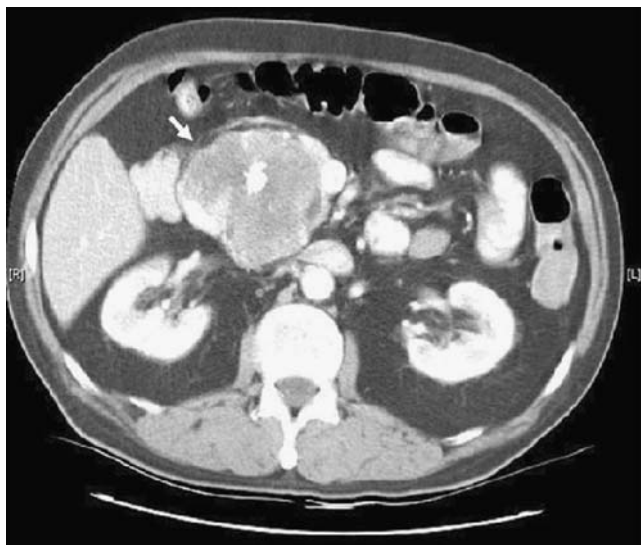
Contrast-enhanced CT scan demonstrating a large mass measuring 6.5×8 cm in the head of the pancreas (*arrow*) with central dystrophic calcifications.
